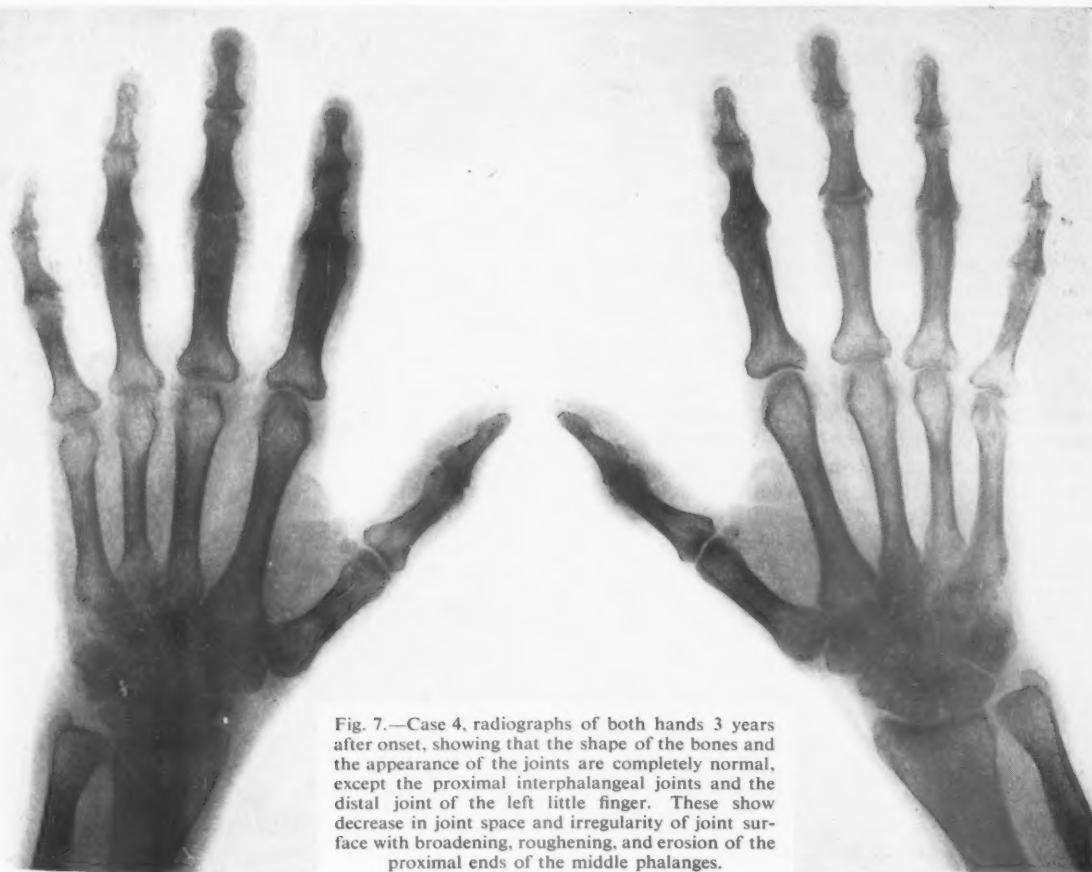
Case 4, radiographs of both hands 3 years after onset, showing that the shape of the bones and the appearance of the joints are completely normal, except the proximal interphalangeal joints and the distal joint of the left little finger. These show decrease in joint space and irregularity of joint surface with broadening, roughening, and erosion of the proximal ends of the middle phalanges.
